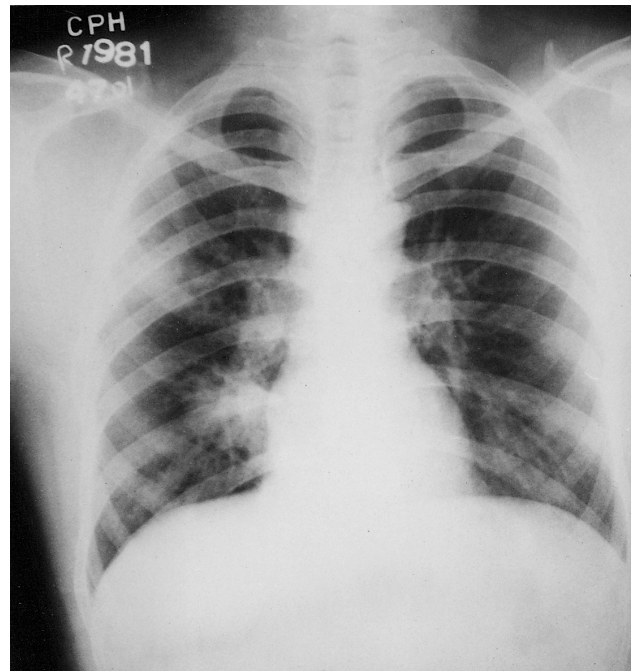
Chest X-ray revealing infiltrates in the right mid and lower lung fields.
